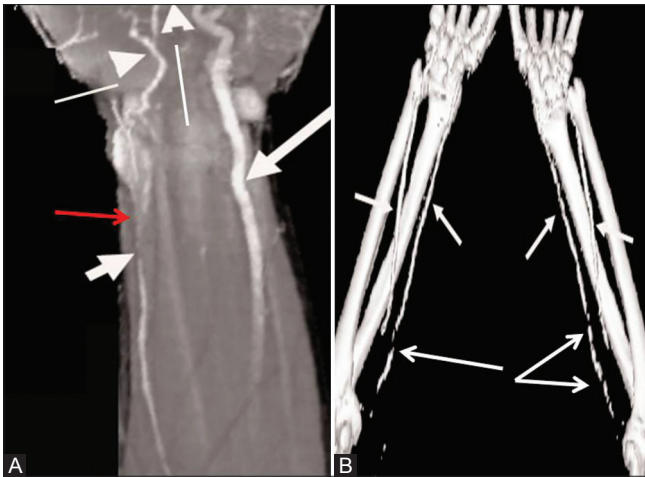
(A and B): (A) The anterior projection at the level of the hand reconstitution of the radial artery distal to occlusion (red arrow and short white arrows). Deep palmar arch (arrowheads) through the ulnar artery (long arrow on the right side) that explains the reason for normal Allen test in this patient; (B) Unenhanced computed tomography shows diffuse and dystrophic calcification of bilateral radial and ulnar arteries (arrows). Computed tomographic angiography shows patency of proximal ulnar and radial arteries, diffusely calcified segments cannot be evaluated
